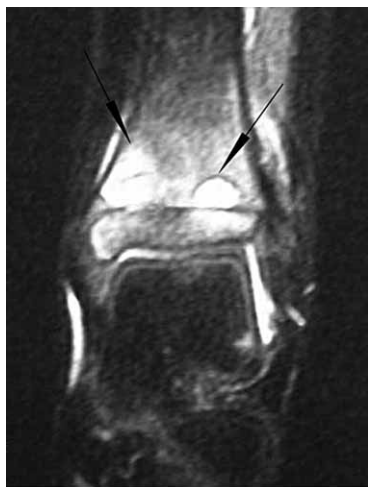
MRI of the left ankle show two osteolytic foci (black arrows) above epiphyseal cartilage plate involved in the tibial metaphyses with denivelation of cortical bone and signs of swelling of the surrounding spongiosis.
